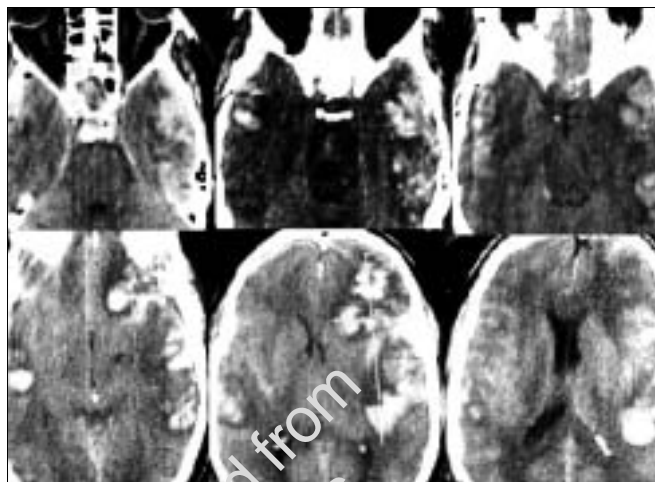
Second CT scan of case 2 showing significant increase in temporal contusions. This patient was operated after 2<sup>nd</sup> CT scan
